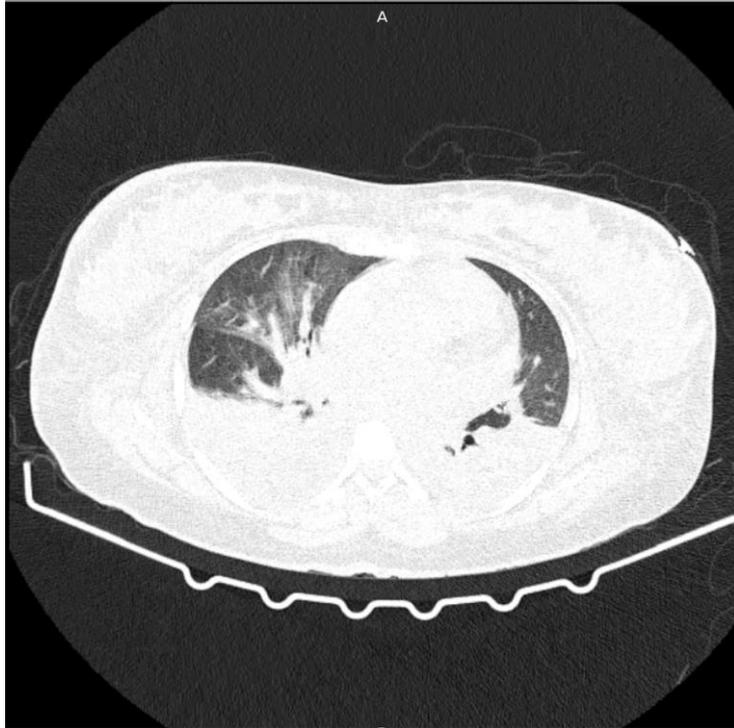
CT Pulmonary Angiogram
